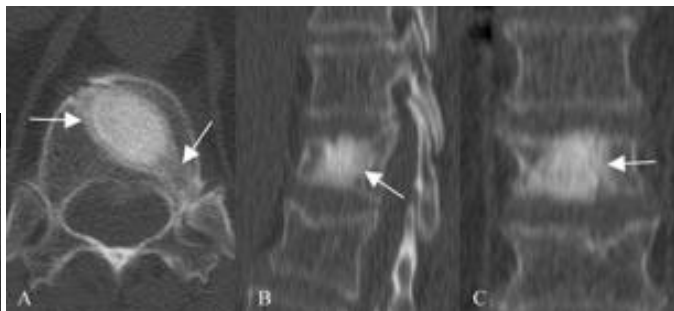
L1 fracture in a 73 y.o. female, DEXA T-score of -2.0. In all 6 month CT views, demarcation of the mesh border is blurred and there is a zone in between the native vertebral bone and the dense graft pack in the middle of the mesh. This zone appears to be incorporated graft and new bone (arrows), particularly in the access tunnel for mesh insertion seen in Fig. A.
